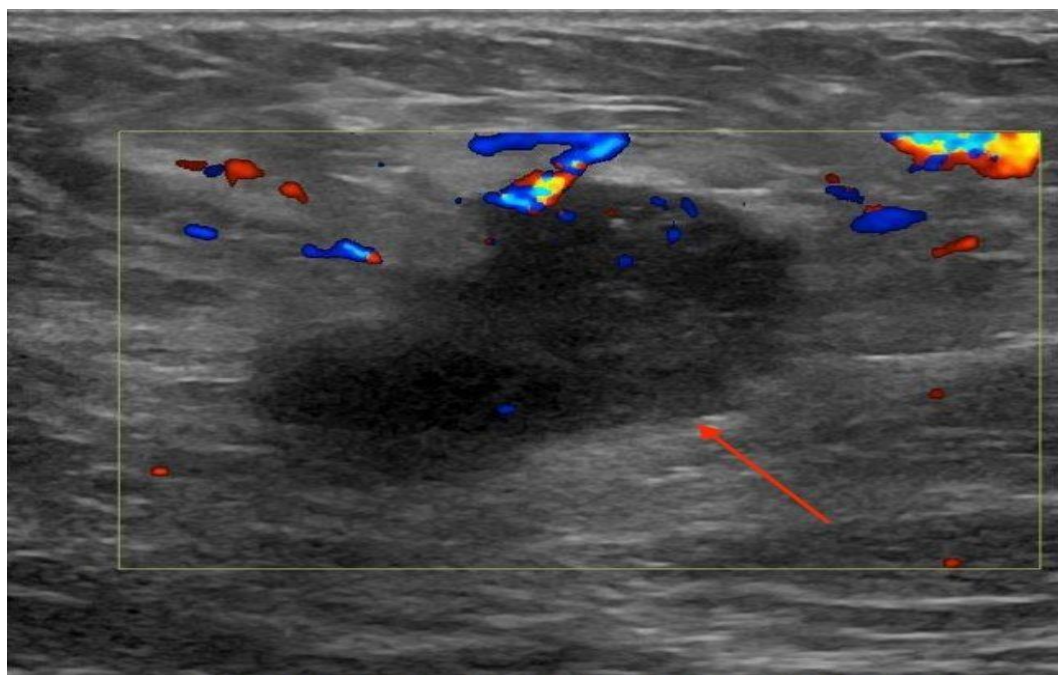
A breast ultrasound showing a heterogeneous mass with varying internal echogenicity, associated with increased Doppler flow in the right breast (arrow).
